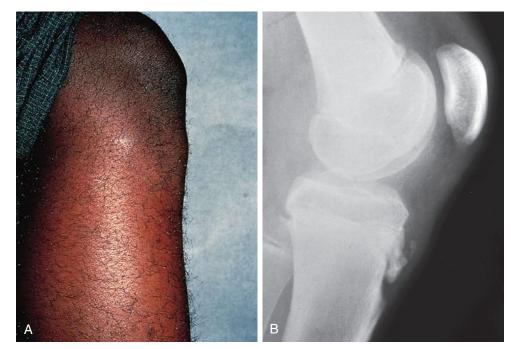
Osgood-Schlatter disease. A, Localized swelling is evident in the region of the tibial tubercle. This is generally tender on palpation. The knee is otherwise normal on examination, with the possible exception of mild limitation of flexion. B, Irregularity and fragmentation of the tibial tubercle are seen in this radiograph. In less severe cases of shorter duration, soft tissue swelling or irregularity of ossification may be the only finding.
